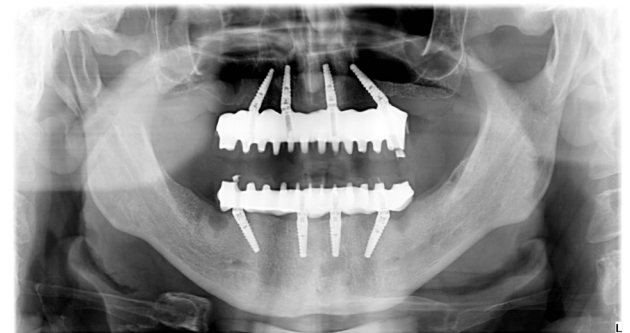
Final orthopantomography.*
